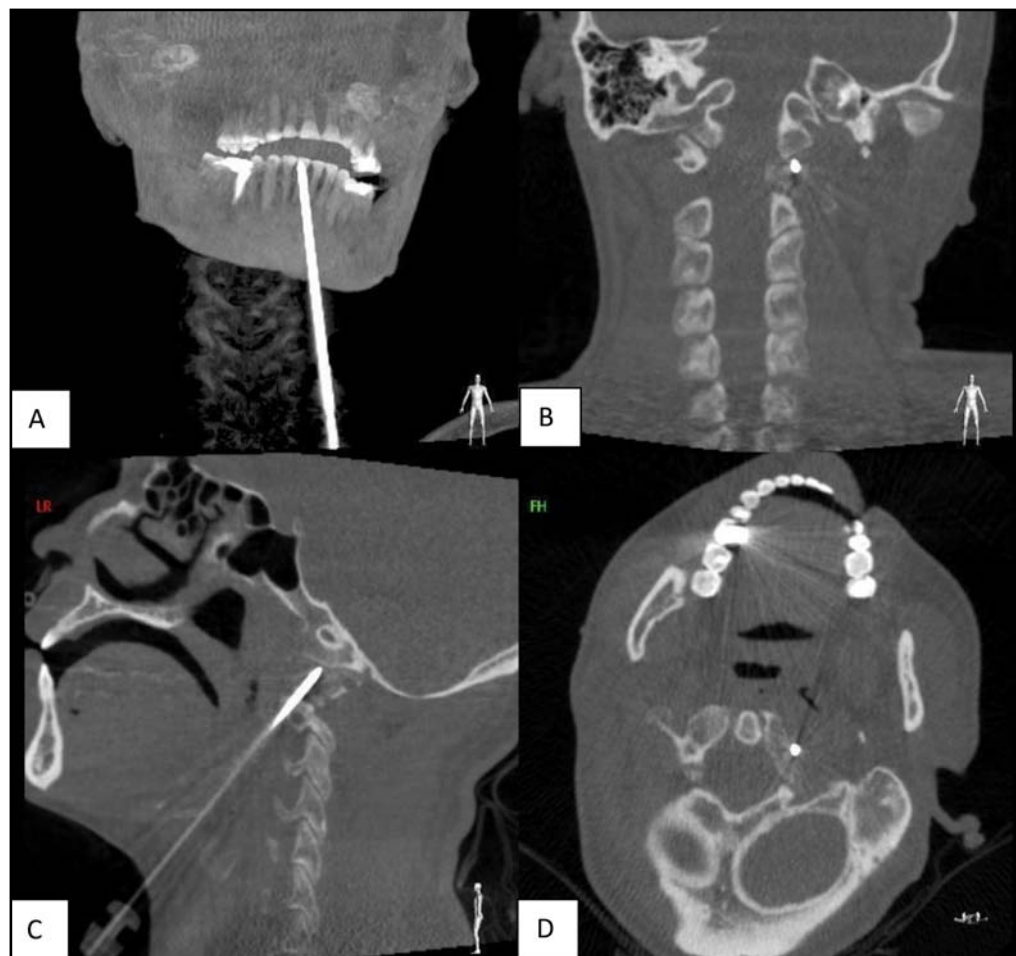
The three-dimensional reconstruction of C-arm CT scan confirmed that the 13G puncture needle was located in the left lateral mass of the C1 vertebral metastases without injuries to adjacent organs. (A). Front view; (B). Rear view; (C). Side view. (D) Aerial view.
